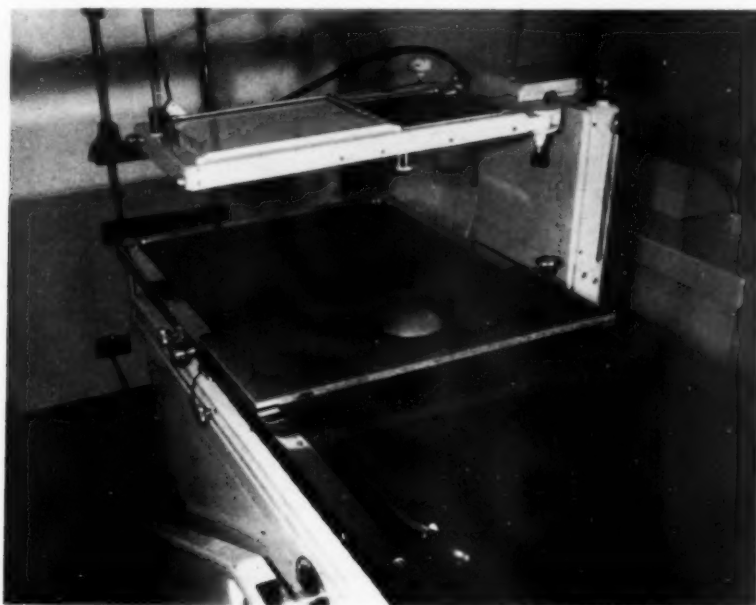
The compression device with balloon inflated, in position for fluoroscopy on the radiographic table. The pneumatic compressor automatically centers the part to the center of the Potter-Bucky diaphragm.
